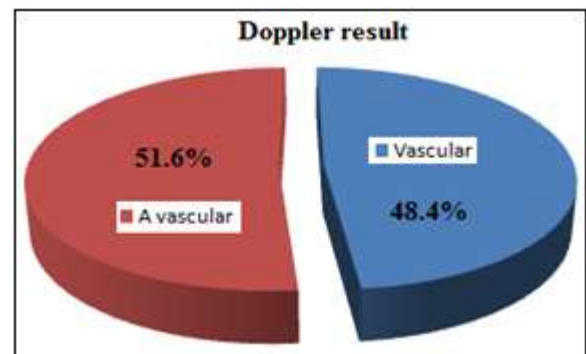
Shows breast masses Doppler flow pattern. (n = 62)
